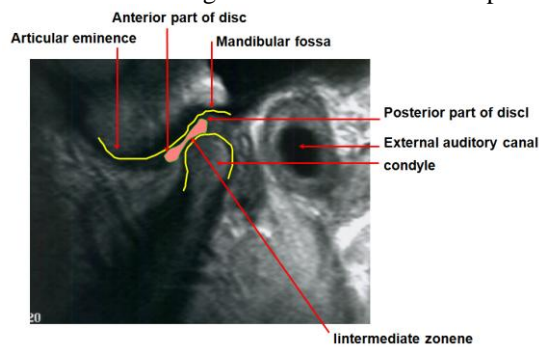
MR image with graphical visualization of the structures in question
